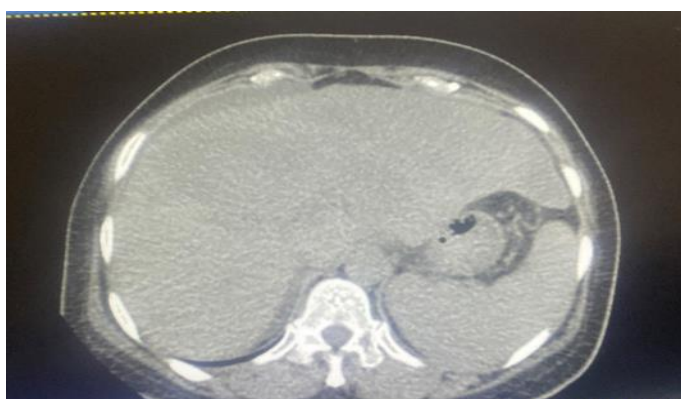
Axial CT non contrast showing an ill-defined heterogenous liver texture
